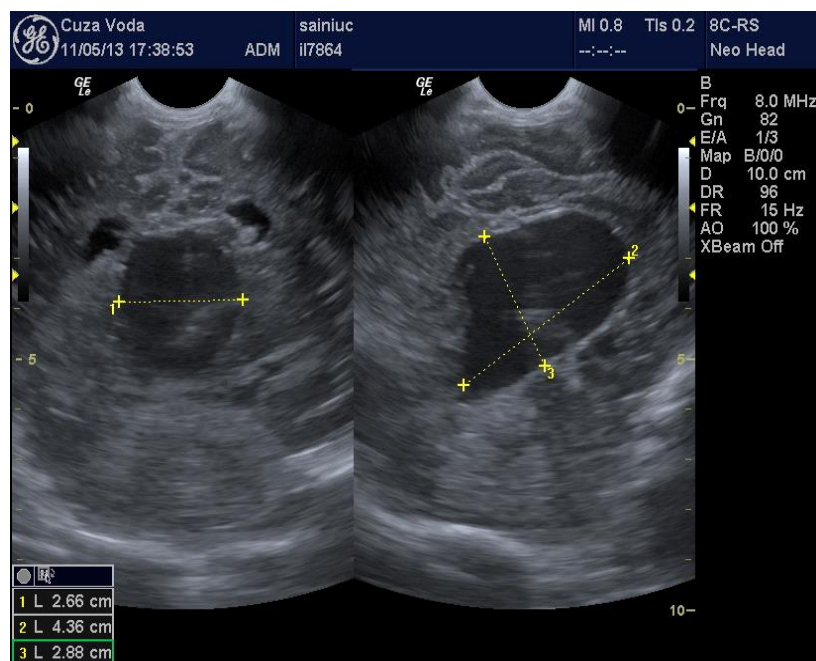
Transfontanelar 2D ultrasound in the newborn.
